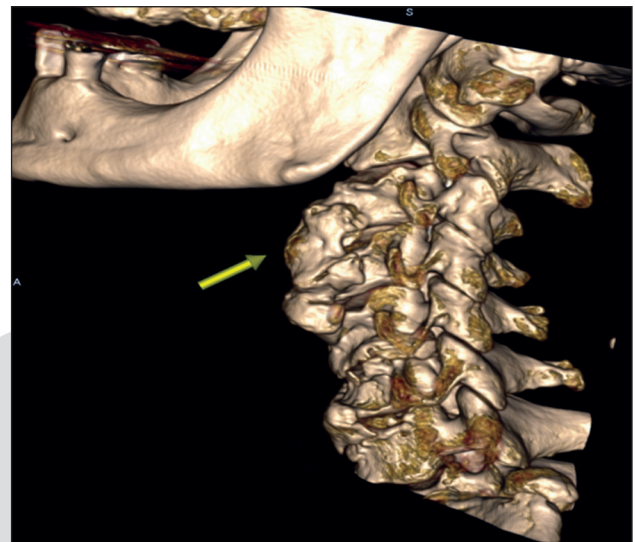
3D CT image; the osteophytes formation at anterior corpus vertebra at the level of C3-C5 is seen
